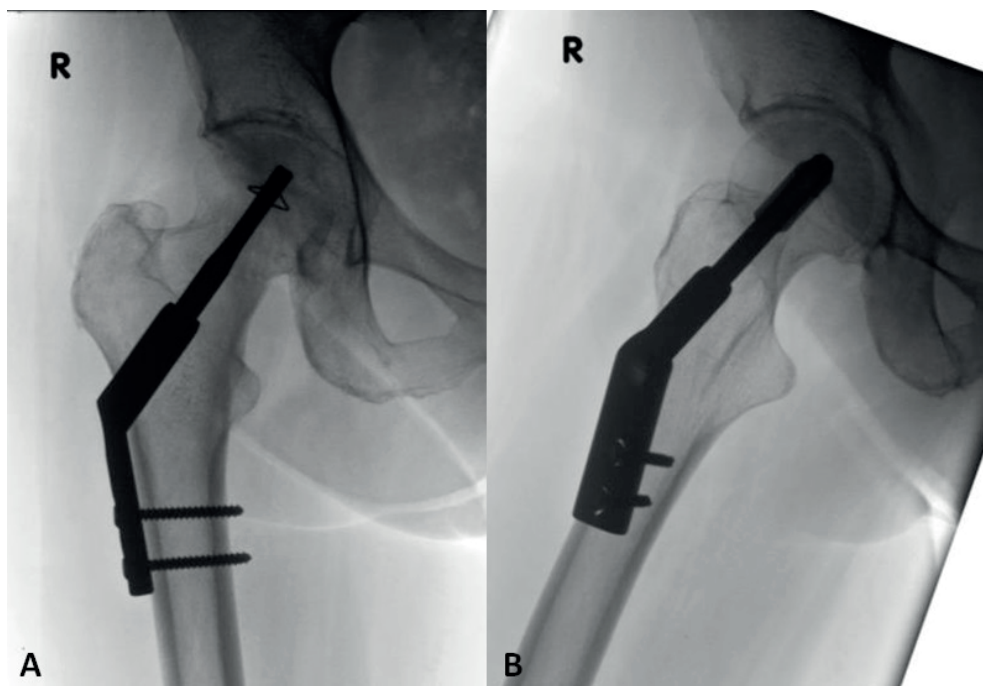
Intraoperative radiograph of the Dynamic Locking Blade Plate fixing a Femoral Neck Fracture.
